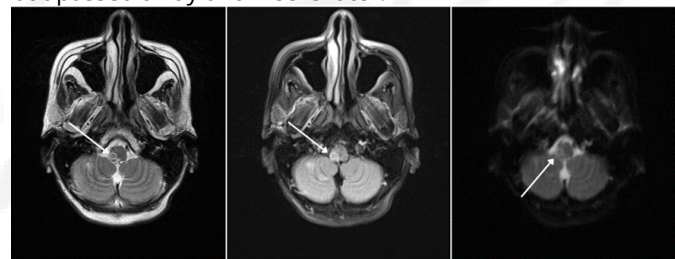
Axial T2-weighted and FLAIR MRI images showing focal area of hyperintensity involving dorsolateral medulla on the right side, suggestive of infarct. Axial diffusion weighted MRI image showing focal area of diffusion restriction in dorsolateral medulla on the right side, suggestive of acute infarct.
